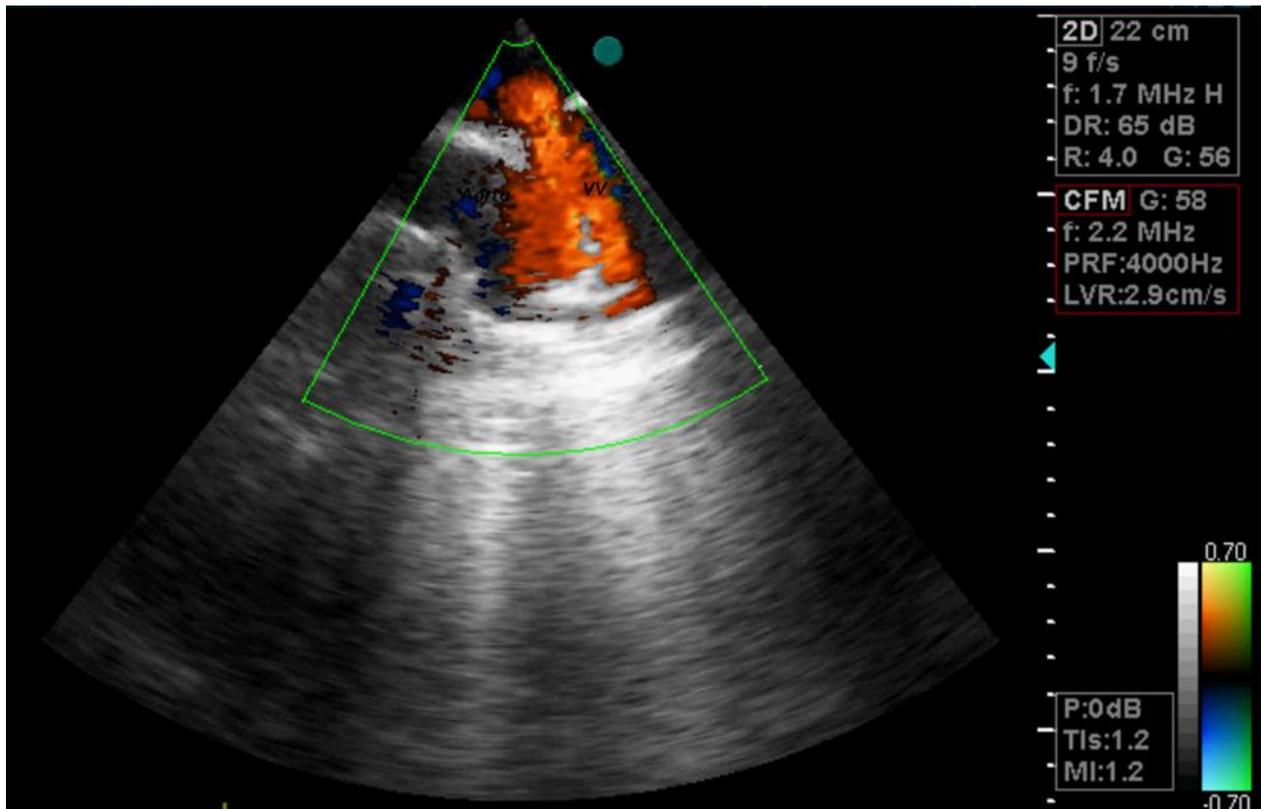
Suprasternal echocardiographic view demonstrating left vertical vein(VV) with direction of flow towards transducer
